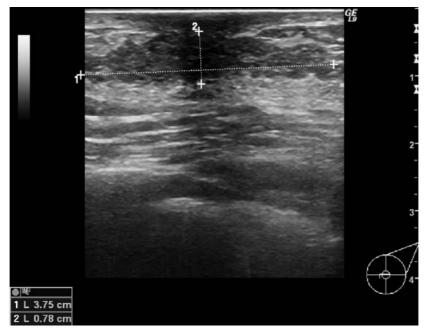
Ultrasound examination of breast tissue of a 71-year-old man showing a well-defined hypoechoic discoid area compatible with gynaecomastia 3.75 cm in width (line 1) and 0.78 cm in depth (line 2). Neither ultrasound examination nor mammography is usually needed in the routine work-up of patients, but should be restricted to situations where there is doubt whether an enlargement of the breast tissue represents gynaecomastia or lipomastia. If a breast cancer is suspected a biopsy should be performed.
